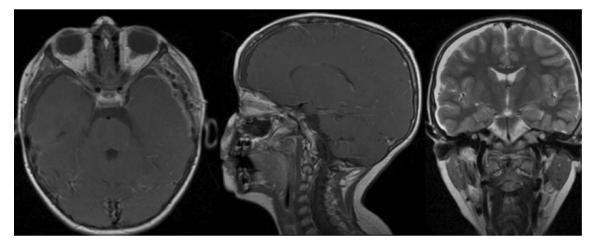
Case 1, early postoperative MRI shows no residual tumor
